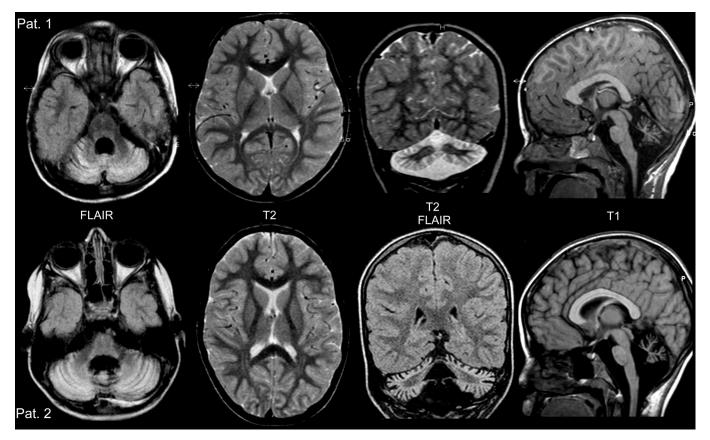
MRI of Patients 1 and 2 demonstrates hyperintensity of the cerebellar cortex, widened cerebellar fissures, and an enlarged fourth ventricle in the absence of basal ganglia changes.
